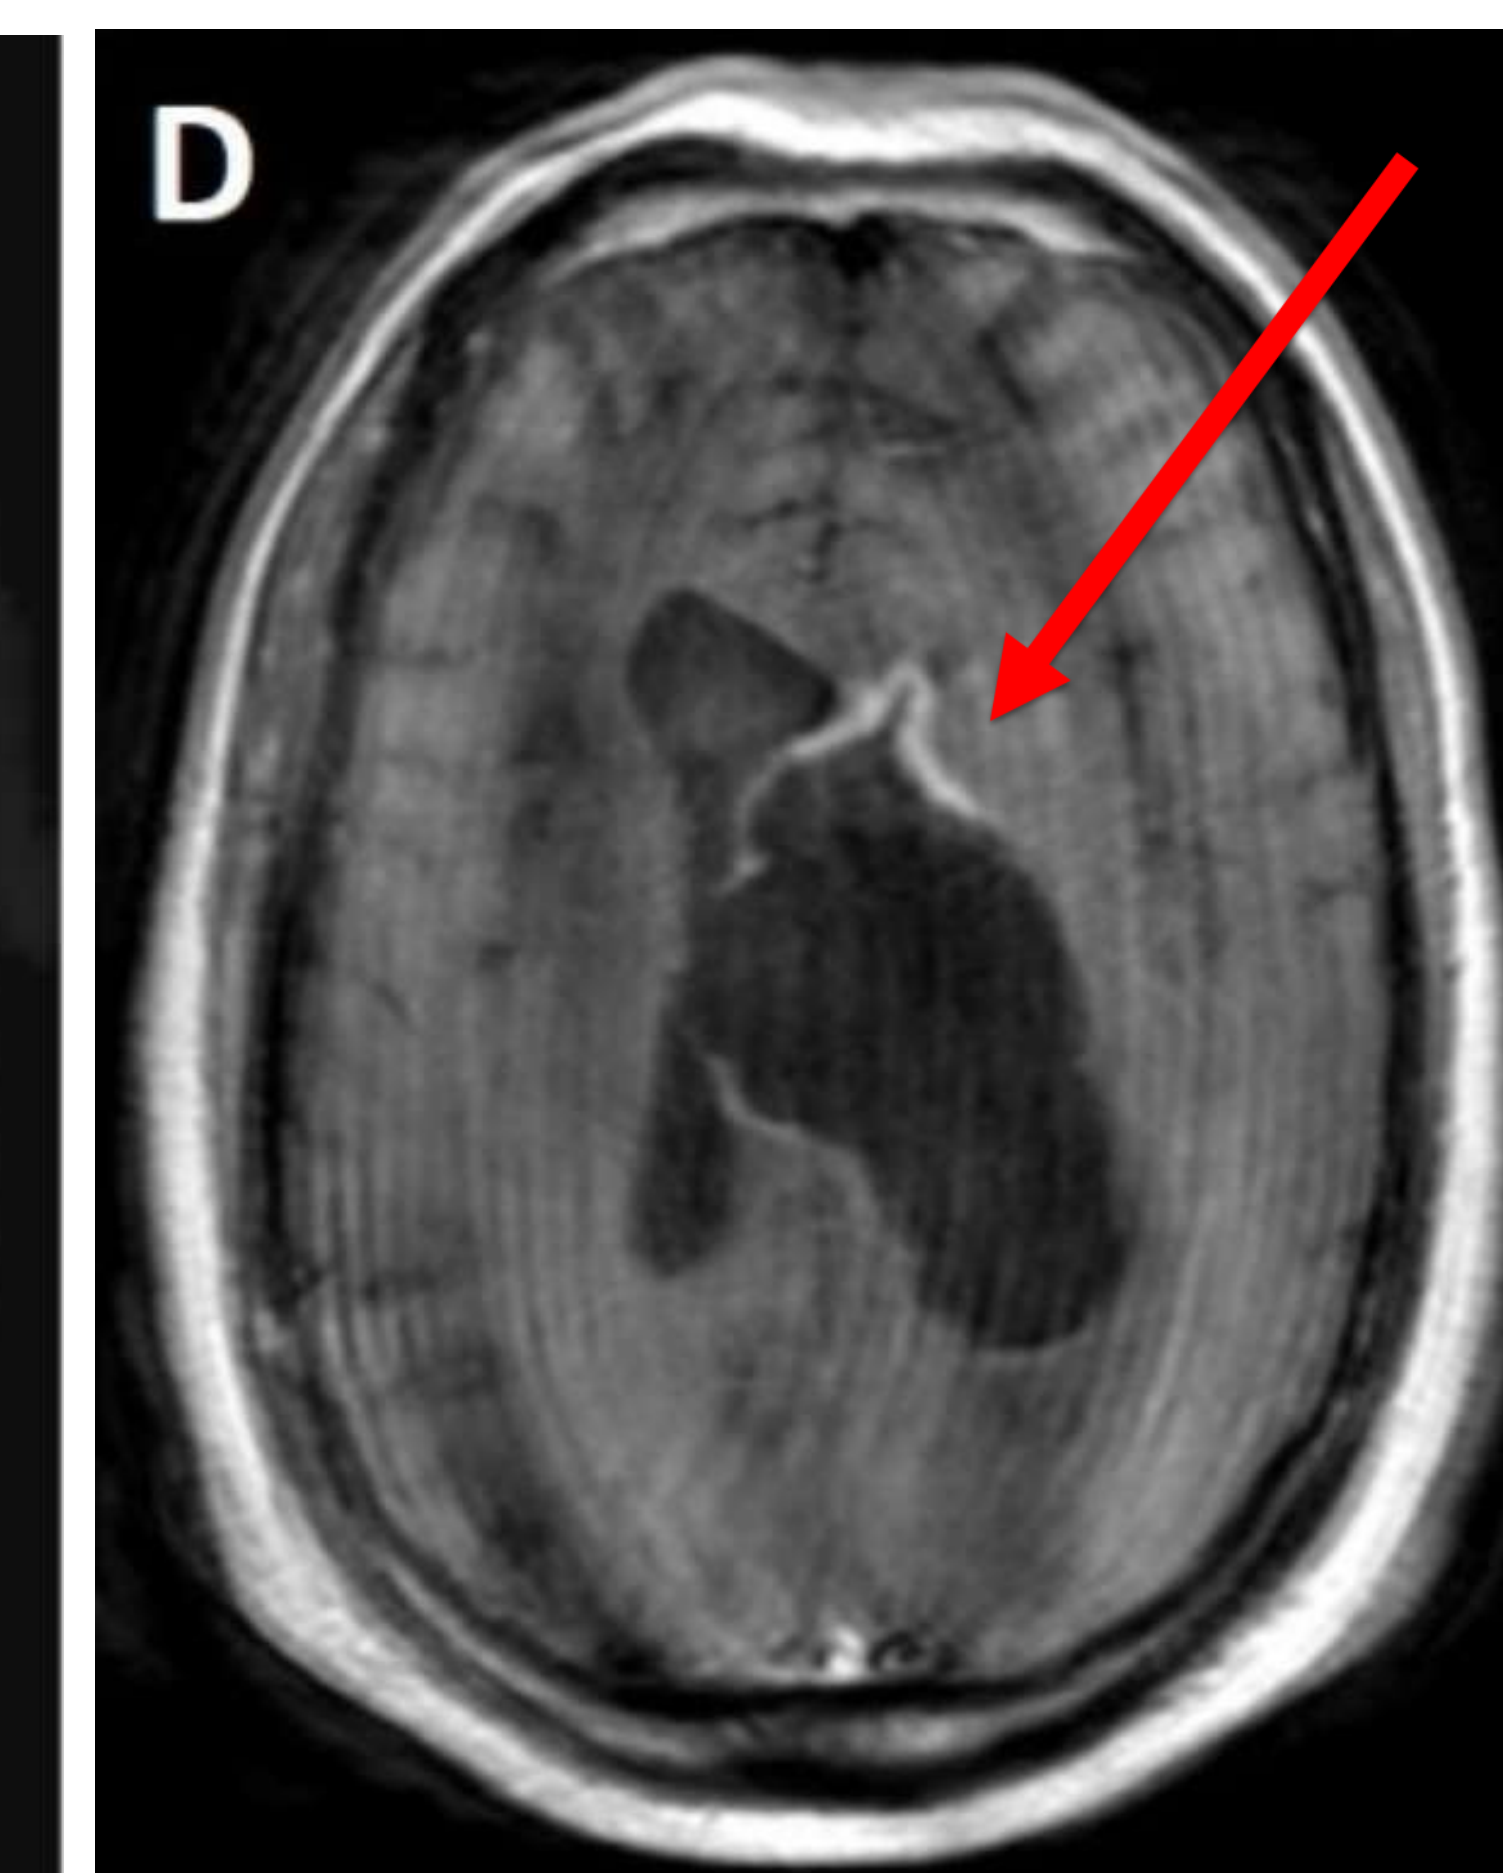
Axial MR T1 post-contrast sequence demonstrates peripheral enhancement along the anterior margin (red arrow) of the hyperintense FLAIR lesion within the left lateral ventricle. Note that there is no internal enhancement identified within the lesion.
